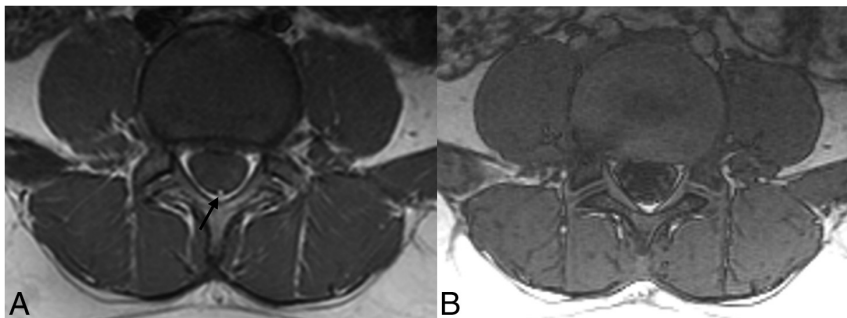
Different acquisitions of T1-weighted MR imaging on the axial plane through the lumbar region at the L4–L5 intervertebral disc in a 10-year-old boy. A, A T1 FSE sequence shows a tiny, round, midline intradural lesion (black arrow) with bright signal intensity located posteriorly in the spinal canal at the expected anatomic site of the filum terminale, consistent with a FIL. B, VIBE of the same patient at the same level shows iso-signal intensity nerve roots of the cauda equina traversing the spinal canal. Although the window level and width are adjusted for better detection of bright lesions, the VIBE sequence failed to reveal the FIL. Note the smaller AP and RL dimensions of the FIL compared with the case in Fig 3. The VIBE sequence is less sensitive in the detection of small FILs and can miss such lesions.
